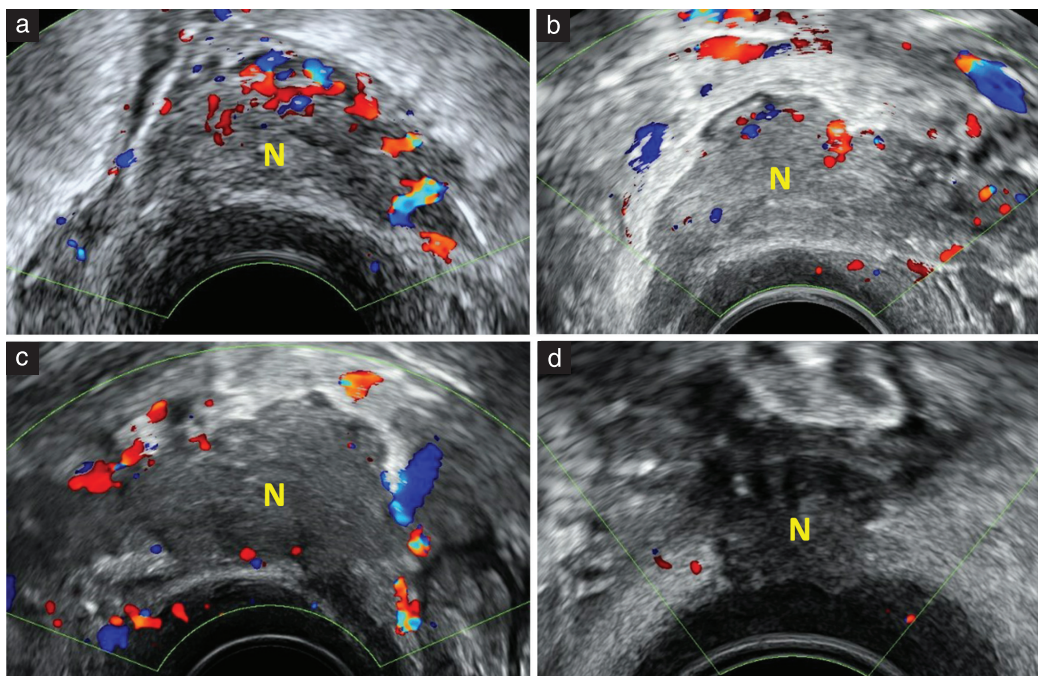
Transvaginal color Doppler images showing longitudinal view of posterior pelvic compartment in 32-year-old multiparous patient with known history of pelvic endometriosis and rectovaginal nodule (27 mm mean diameter) that was managed expectantly prior to pregnancy. (a) Examination at 12 weeks' gestation revealed solid hyperechoic lesion with irregular blurred borders measuring 30 mm in mean diameter that was fixed to neighboring bowel and demonstrated increased vascularity, in keeping with decidualized endometriotic nodule (N). (b,c) As pregnancy progressed, nodule reduced in size, measuring 28 mm in mean diameter at 20 weeks (b) and 25 mm at 32 weeks (c). (d) At postnatal follow-up, nodule measured 13 mm in mean diameter and all features of decidualization had resolved.
